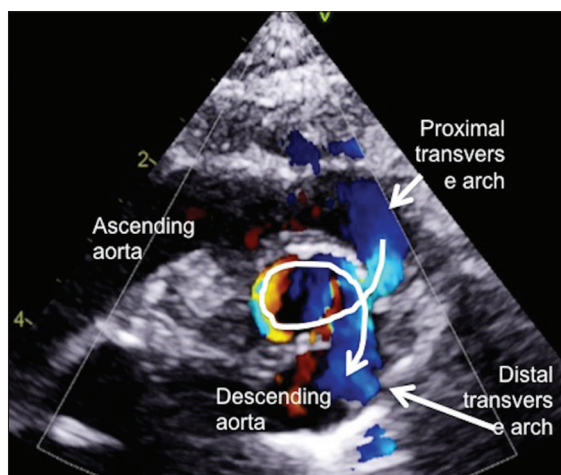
Suprasternal long-axis view of the aortic arch shows marked corkscrew tortuosity of the distal aortic arch with turbulent color Doppler flows
